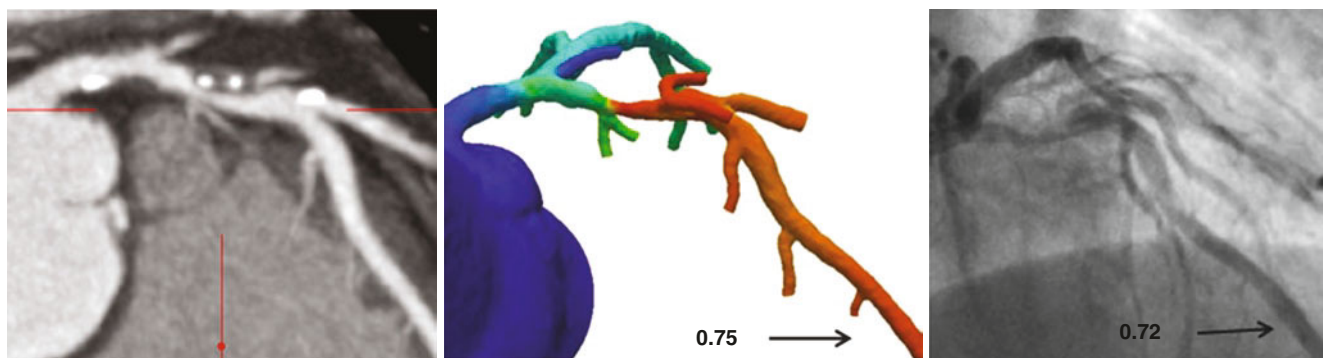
This patient with multivessel calcific disease (calcium score, 1509) had multiple lesions of estimated 50–70% luminal stenosis. Each vessel territory was found to be ischemic by  $FFR_{CT}$ , which was corroborated invasively
